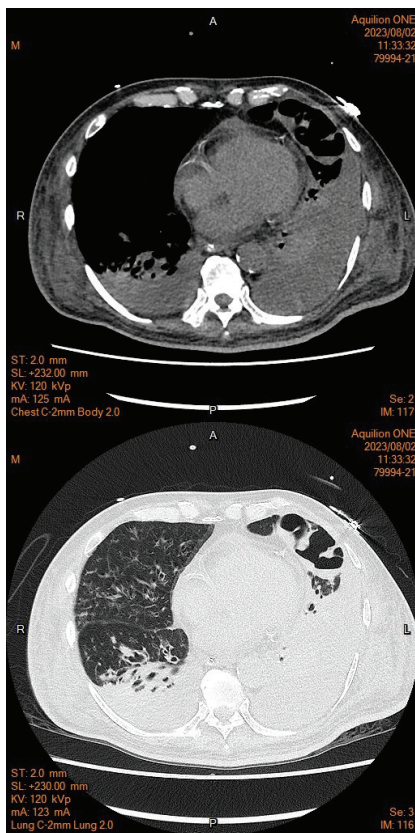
Chest computed tomography scan demonstrated multifocal ill-defined peribronchial opacities, patchy consolidations in both lungs, bilateral pleural effusions, bronchiectasis in the right lower lobe, and a lung abscess in the left upper lobe.
